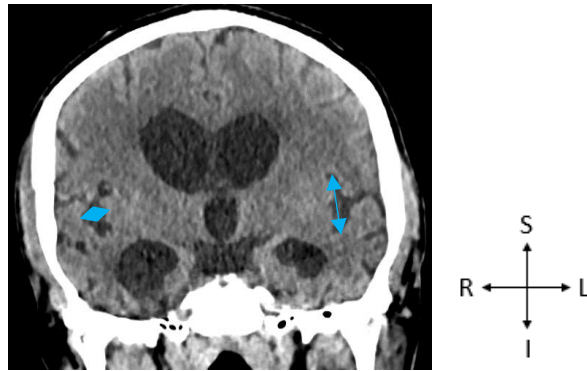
A CT scan of the brain in the coronal view indicating the Sylvian fissure width (left blue arrow) and height (right blue arrow). Image taken from the GSH PACS (20 October 2023). S - Superior, R - Right, I - Inferior, L - Left.
